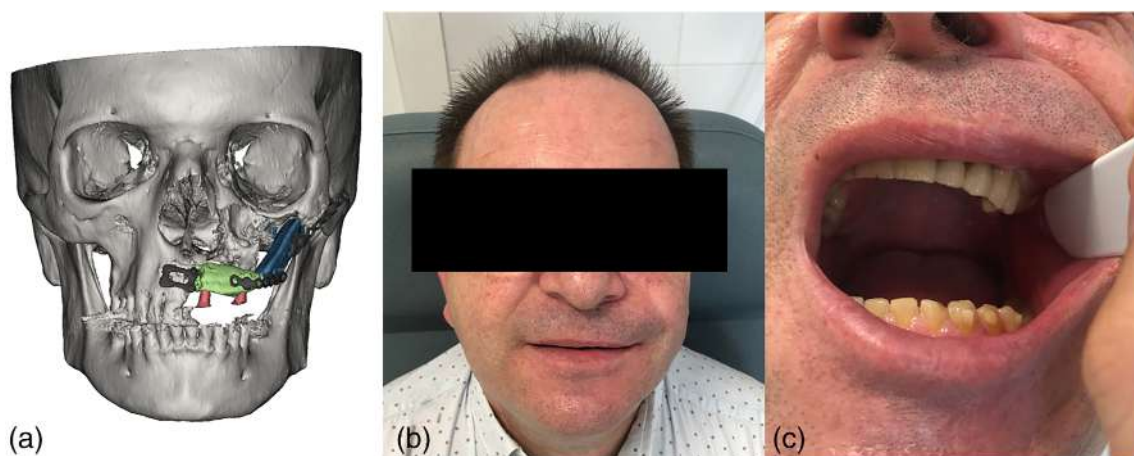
(a) Postoperative 3D reconstructions using CT scan. ODIs were depicted in red. (b) The latest postoperative image taken from the patient, demonstrating satisfying aesthetic outcomes. (c) Intraoral image showed dental rehabilitation with implants
